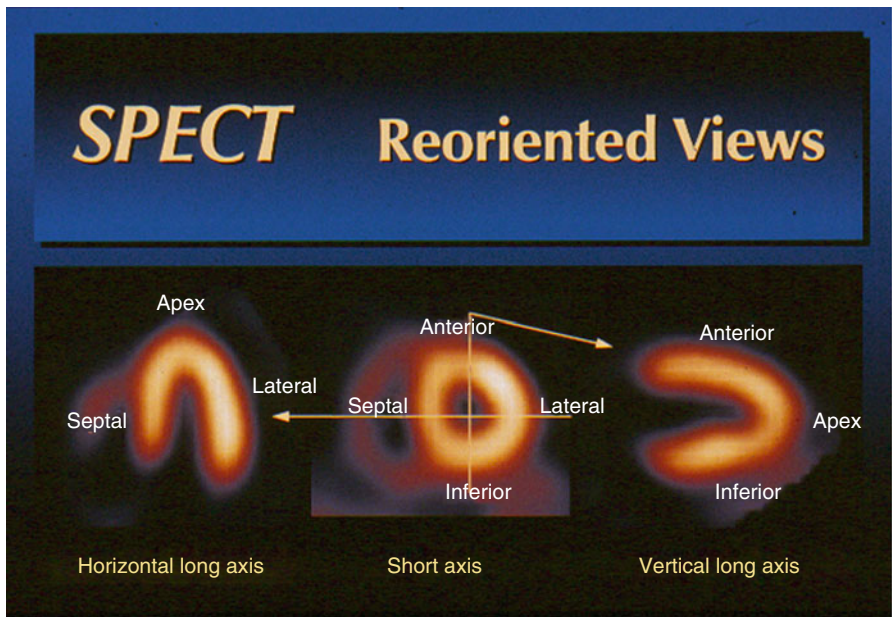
SPECT: Myocardial perfusion scans (Used with permission from Braunwald [27])
